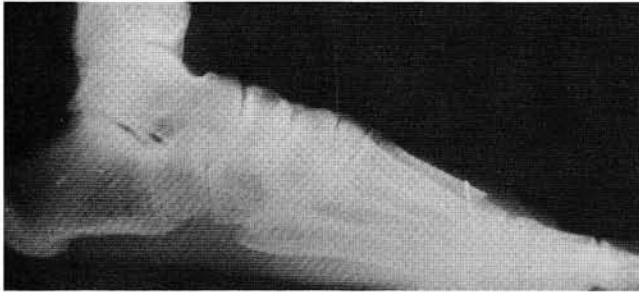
Postoperative lateral weight-bearing radiograph with 0.062 threaded K-wire.
